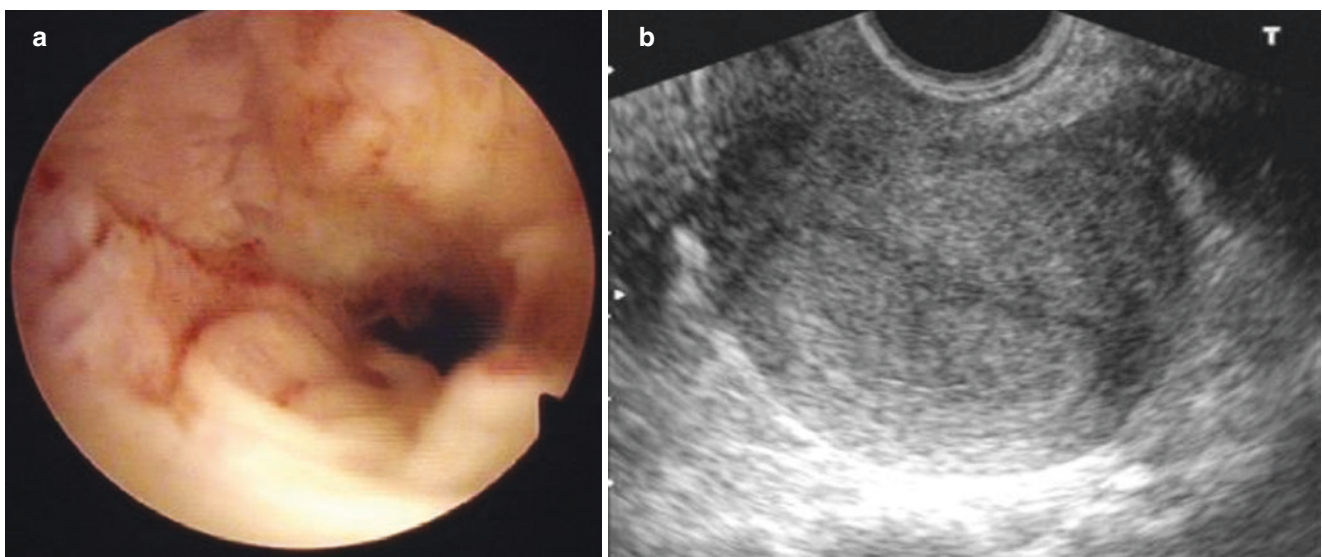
Endometrial hyperplasia. (a) The endometrium is clearly showed by hysteroscopy. (b) thickened endometrium is displayed by ultrasound
